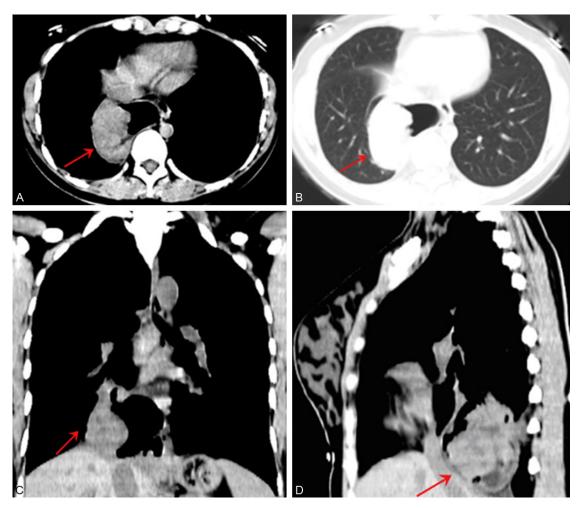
Chest CT show: it could be seen a half hollow abnormal density shadow of the right lower lung and the posterior septum (68 mm×54 mm×60 mm), an eccentric mass lesion in it (38 mm×54 mm×50 mm), and with uneven density, the average of arterial phase was 41HU, solid mass lesion has a clear boundary with a little free air bubble and liquid. The lower esophagus compressed and moved left. The right lower pleural become thick, and the adjacent lung tissue was not completely extended. A little patchy density of the right lower lung was observed, and the edge was fuzzy.
